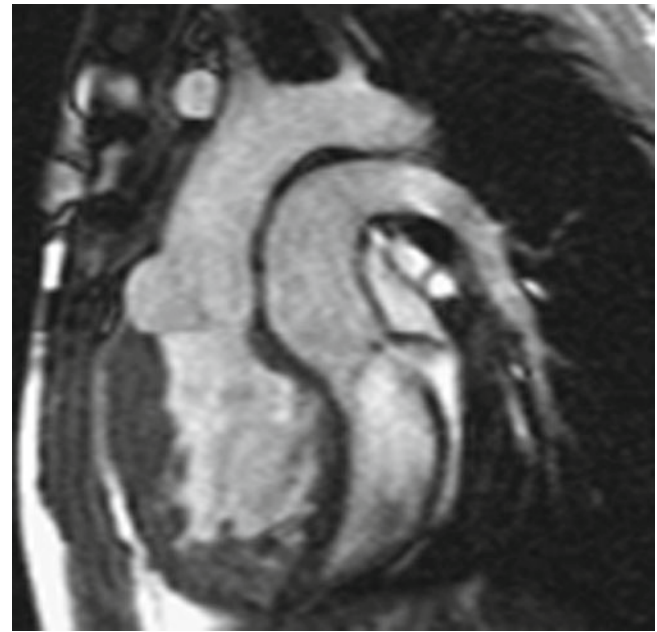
Magnetic resonance imaging of complete transposition of the great arteries. Note anterior aorta arising from a hypertrophied systemic right ventricle and posterior pulmonary artery arising from the left ventricle
